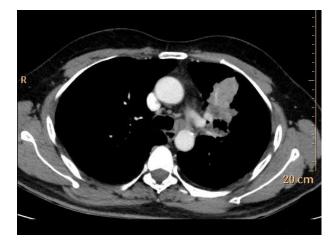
(a): Axial CT shows soft tissue spiculated mass in left hilar region.
